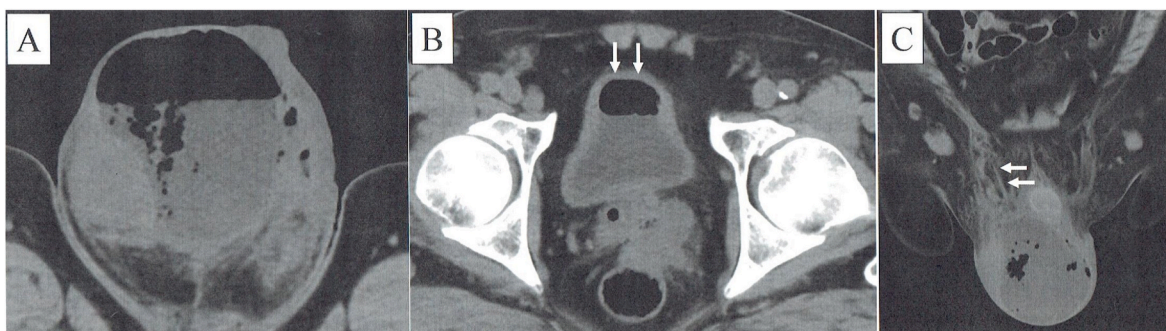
CT findings at admission. A: Intra-scrotal fluid with gas formation. B: Gas formation in the bladder. C: Gas formation in the vas deferens.
